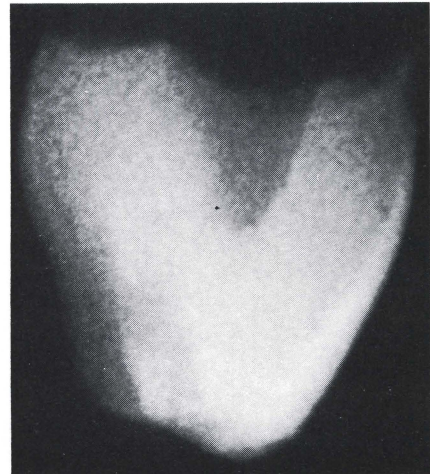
Radiograph taken in a mesiodistal direction. There is no radiographic evidence of a pulpal horn extending into the talon cusp.
